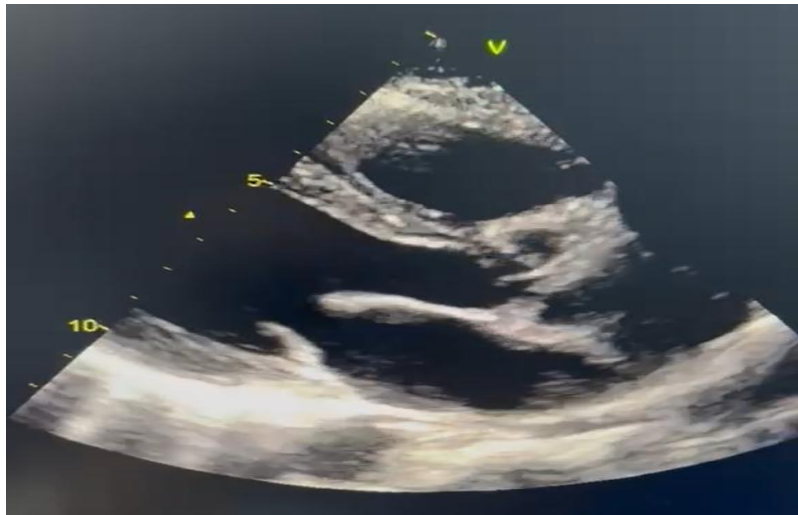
Transthoracic echocardiography, parasternal long axis view (From personal archive)
